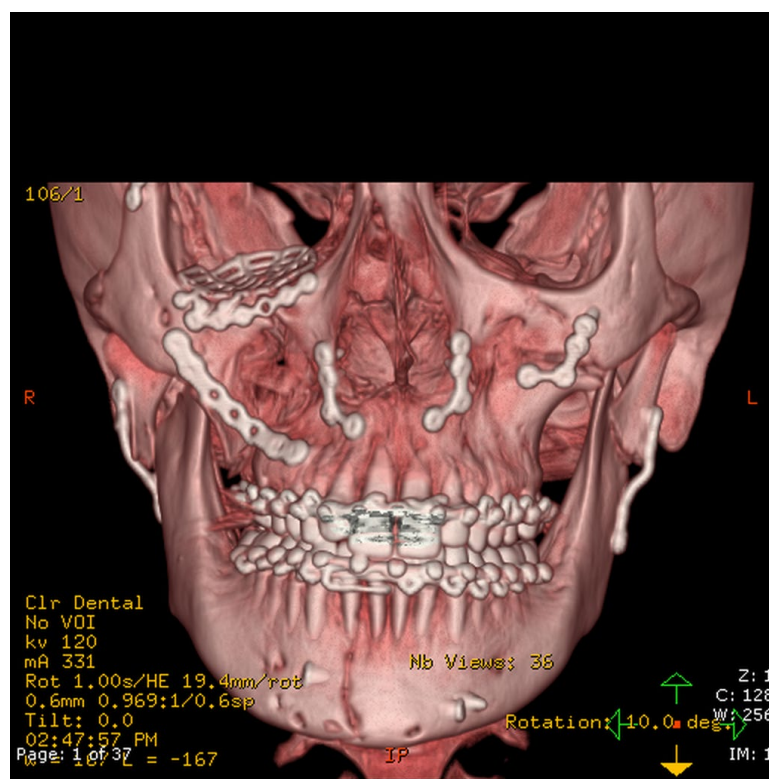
Final postoperative frontal three-dimensional computed tomographic reconstruction demonstrating the restored facial framework and stable hardware after completion of staged fixation.
